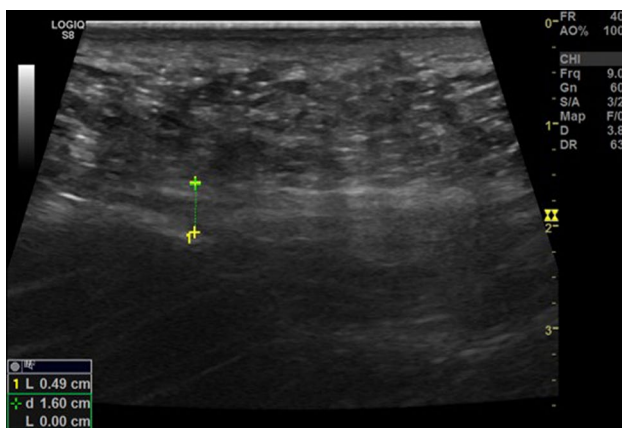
Plantar fascia thickness measured by ultrasonogram in a symptomatic foot
